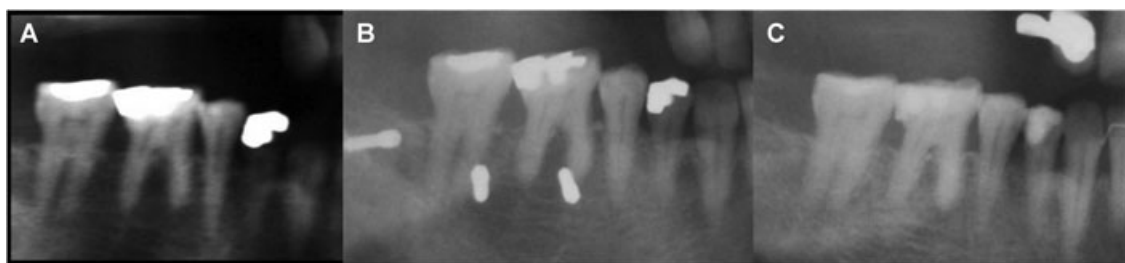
Radiographs of the patient during treatment showing the amount of intrusion. A: initial radiograph before treatment B: radiograph after the insertion of microimplants C: final radiograph after intrusion.
